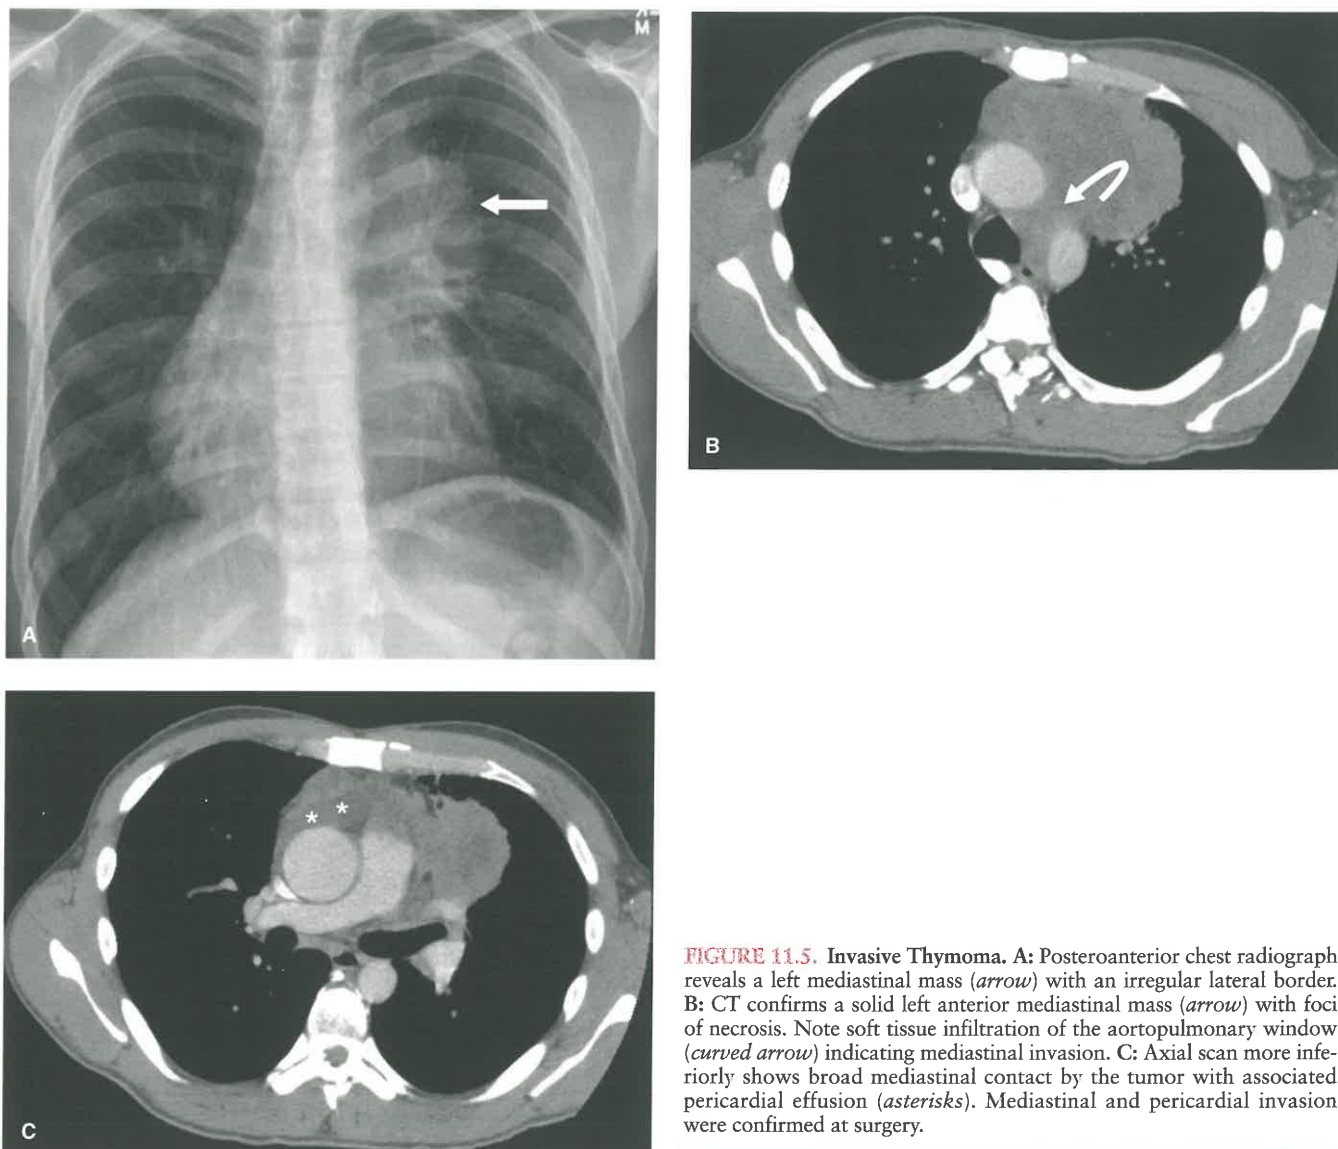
Invasive Thymoma. A: Posteroanterior chest radiograph reveals a left mediastinal mass (*arrow*) with an irregular lateral border. B: CT confirms a solid left anterior mediastinal mass (*arrow*) with foci of necrosis. Note soft tissue infiltration of the aortopulmonary window (*curved arrow*) indicating mediastinal invasion. C: Axial scan more inferiorly shows broad mediastinal contact by the tumor with associated pericardial effusion (*asterisks*). Mediastinal and pericardial invasion were confirmed at surgery.
